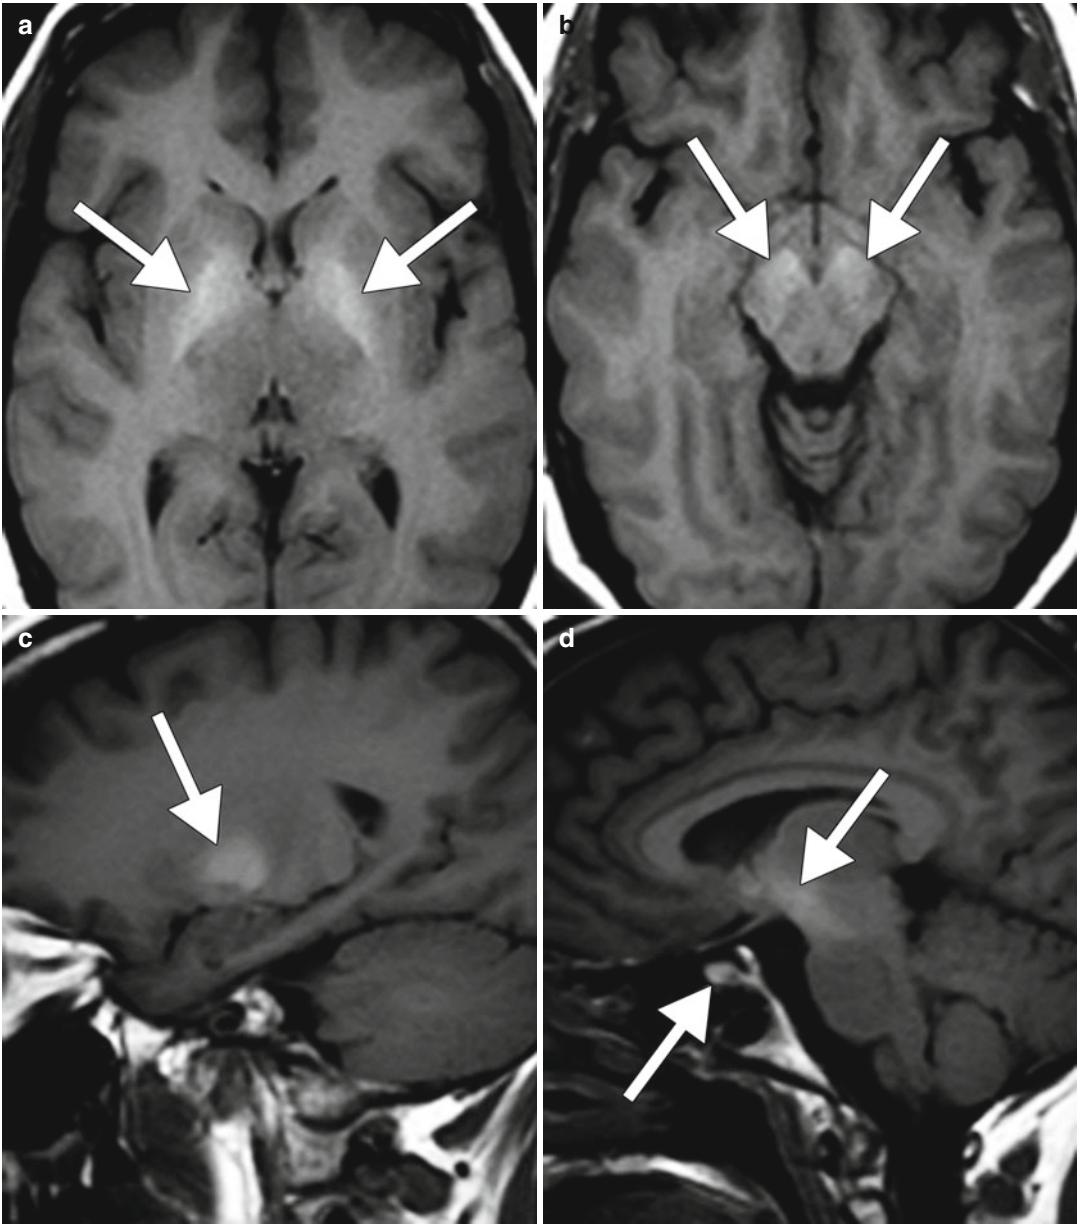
Manganese toxicity in total parenteral nutrition. Axial (a, b) and sagittal (c, d) T1-weighted MRI images show patchy hyperintensity within the bilateral basal ganglia, cerebral peduncles, and anterior pituitary (*arrows*)
